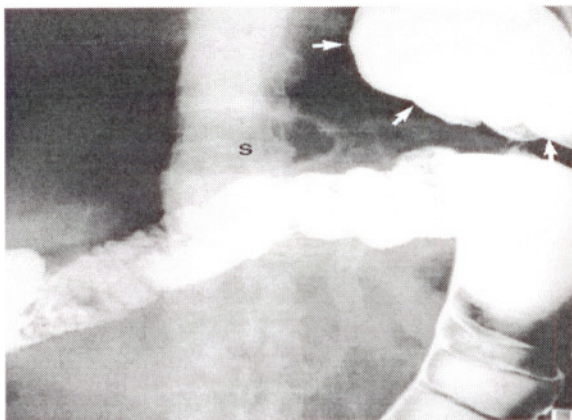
Overhead radiograph of the left midabdomen from a barium enema study. Small arrows outline the splenic flexure area of the colon herniating through the left hemidiaphragm. The gas filled stomach (S) is in the normal subdiaphragmatic location.
